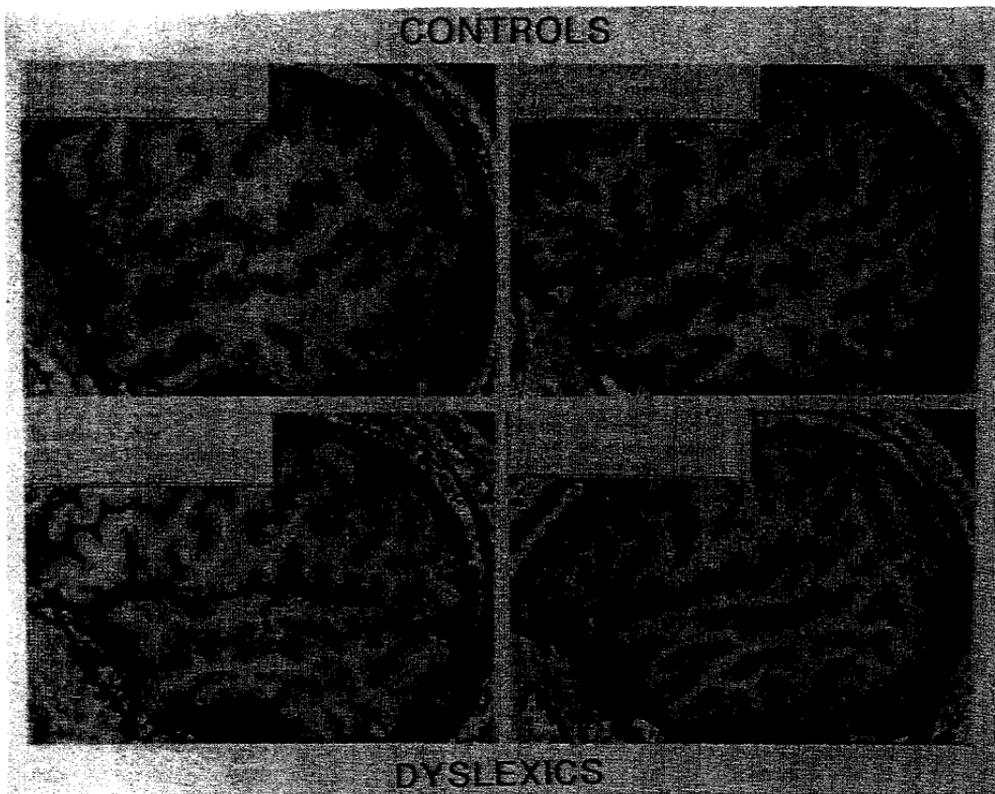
Magnetic resonance image of two controls and two dyslexic subjects from the Leonard, et al. (1993) study. The controls have either the typical bifurcation (*left*) or an ascending parietal bank (*right*) that enters a clearly demarcated supramarginal gyrus. Arrowheads mark the borders of the temporal bank of the planum. The two dyslexic subjects have multiple primary sulci and extra gyri in the parietal operculum (stars) and/or multiple Heschl's gyri (stars in lower right), or all of these anomalies.
